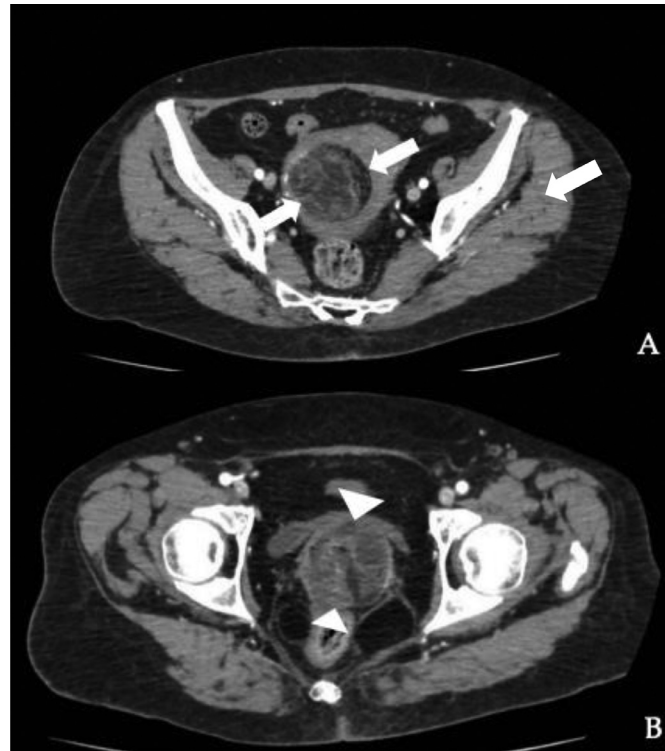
Axial Contrast enhanced CT scan: (A) neoplasm of the uterine corpus (cranial portion) with prevalent adipose component with multiple enhancing septa contextually due to pleomorphic LPS (arrows). (B) tumor tissue in the cervix (caudal portion) with contrast enhancing solid fraction and minor fat component due to L-LMS (arrowheads).
